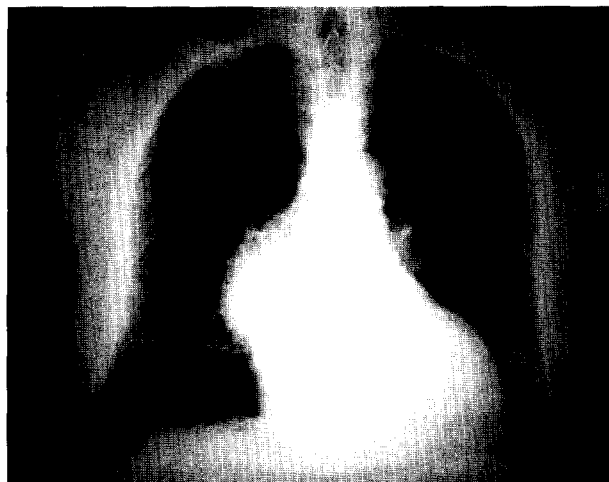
Posteroanterior chest roentgenogram showing right hilar mass.
